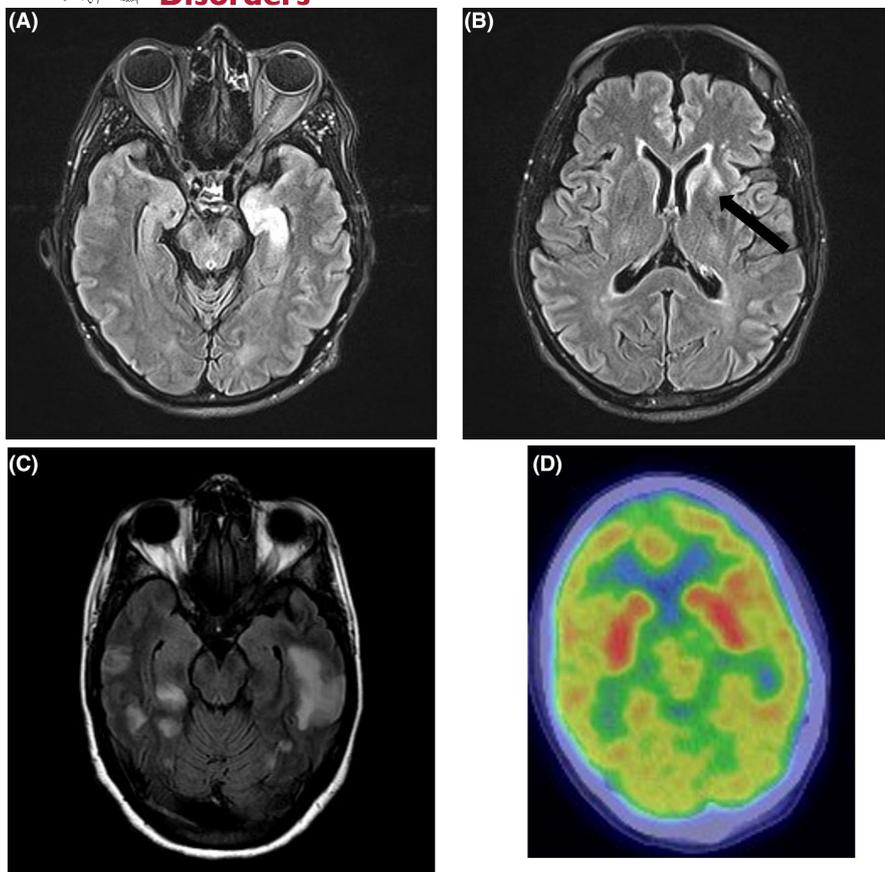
Imaging findings in autoimmune-associated seizure disorders. (A, B) Imaging in a patient with LGI1 encephalitis shows T2 hyperintensity in the left > right mesial temporal lobe (A) and the left putamen and caudate (B, black arrow). (C) Imaging in a patient with GABA_AR encephalitis showing multifocal T2 FLAIR hyperintensities. (D) Patchy diffuse cortical hypometabolism on FDG-PET in a patient with NMDAR encephalitis with relatively preserved basal ganglia FDG uptake.
